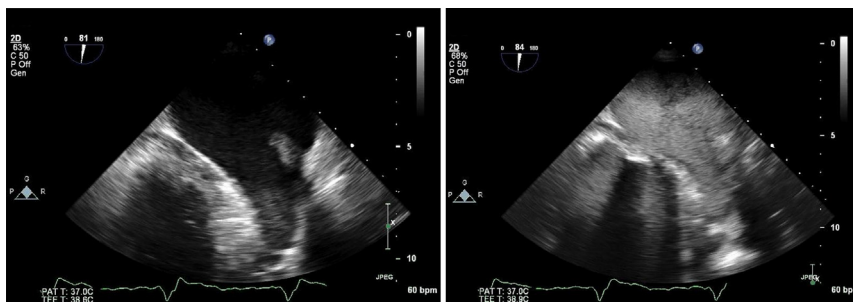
A transesophageal echocardiogram before (*left*) and after (*right*) an IV bolus injection of a transpulmonary contrast agent to confirm that the questionable mass in the left atrial appendage (LAA) was just spontaneous contrast. The IV microbubbles completely fill the LAA (*right*). (See [Video 10](#); available at www.onlinejase.com).
